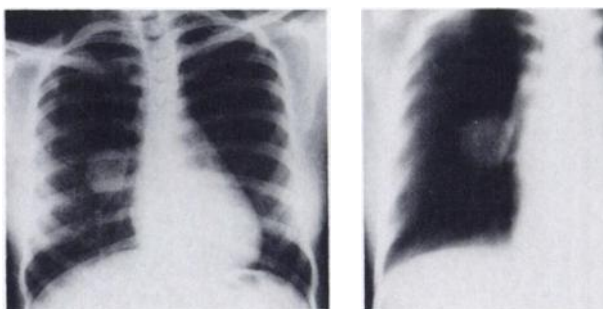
Chest radiograph demonstrates right hilar mass (left). Linear tomography shows homogeneous mass with no deformity of bronchi or pulmonary vessels (right).
